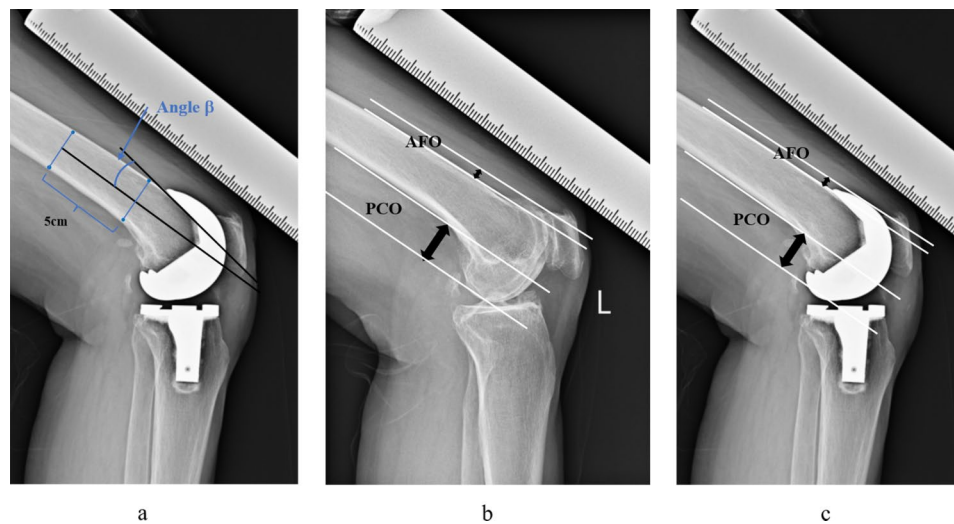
Radiographic analysis. Figure 3a Measurement of femoral prosthesis flexion angle. According to the design of the prosthesis, the femoral prosthesis flexion angle = $\beta - 3^\circ$. (+): flexion, (-): extension. Figure 3b and c Measurement of AFO and PCO. The preoperative(b) and postoperative(c) measurements on lateral radiographs. A cartilage thickness of 2 mm was considered when evaluating the preoperative AFO and PCO. AFO anterior femoral offset; PCO posterior condylar offset
